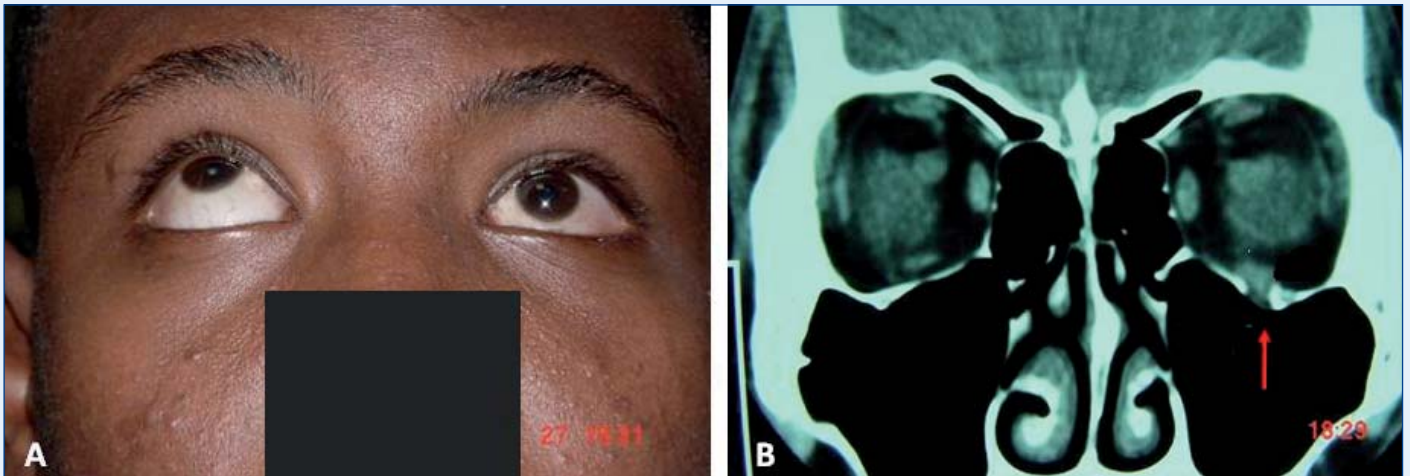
a. Left orbital fracture with limited upward eye movement. b. Computed tomography scan showing a small orbital floor fracture and entrapment of the inferior rectus muscle (arrow).
